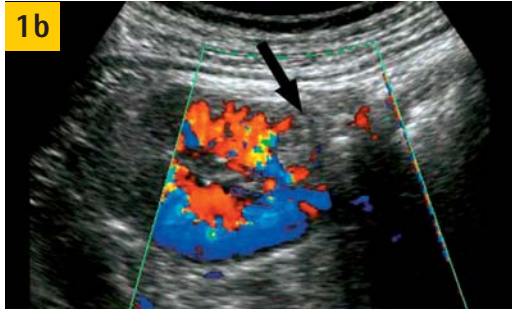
At color Doppler US, the lesion appeared poorly vascular compared to the adjacent cortex.
